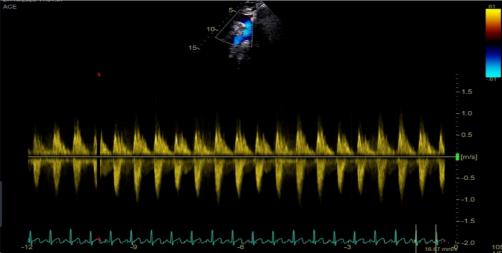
CW doppler of proximal descending aorta suggest respirophasic variation of peak velocity.
